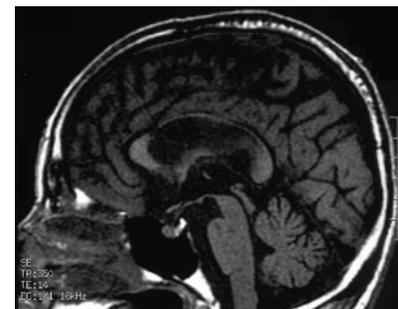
Brain magnetic resonance imaging showed an infarct of the corpus callosum affecting the whole of the body and the anterior half of the splenium.
